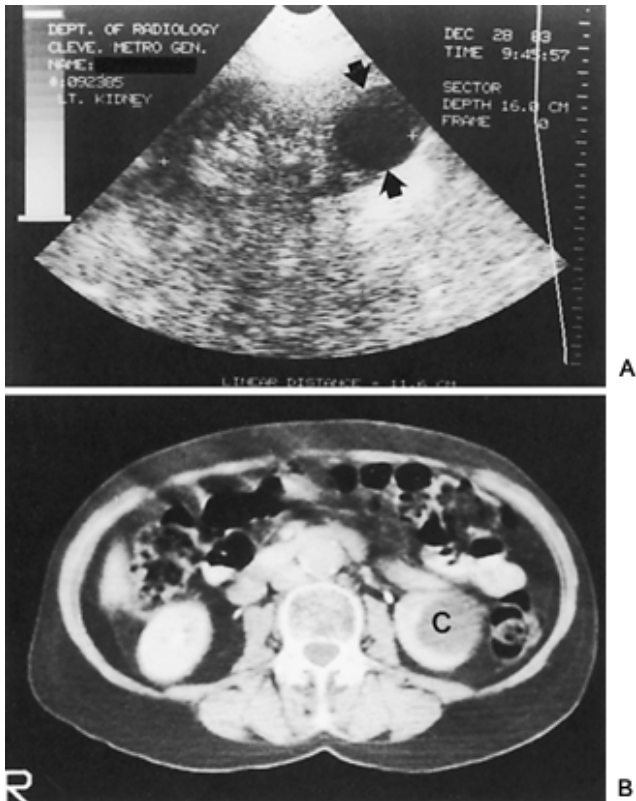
13. A: Longitudinal renal scan showing characteristic findings of a simple renal cyst (*arrows*). B: Cyst (C) demonstrated on computed tomography scan.
